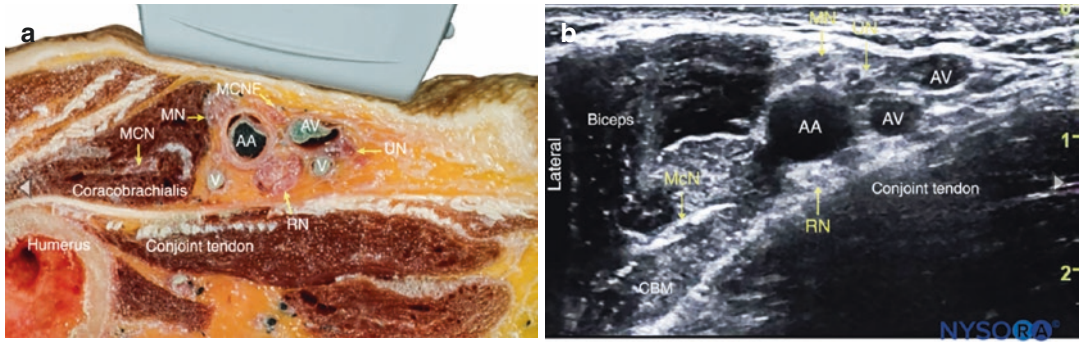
(a) Cross-sectional anatomy of the axillary fossa and ultrasound image (b) of the terminal nerves of brachial plexus. The BP is seen scattered around the axillary artery and enclosed within the adipose tissue compartment containing the axillary artery (AA), and axillary
